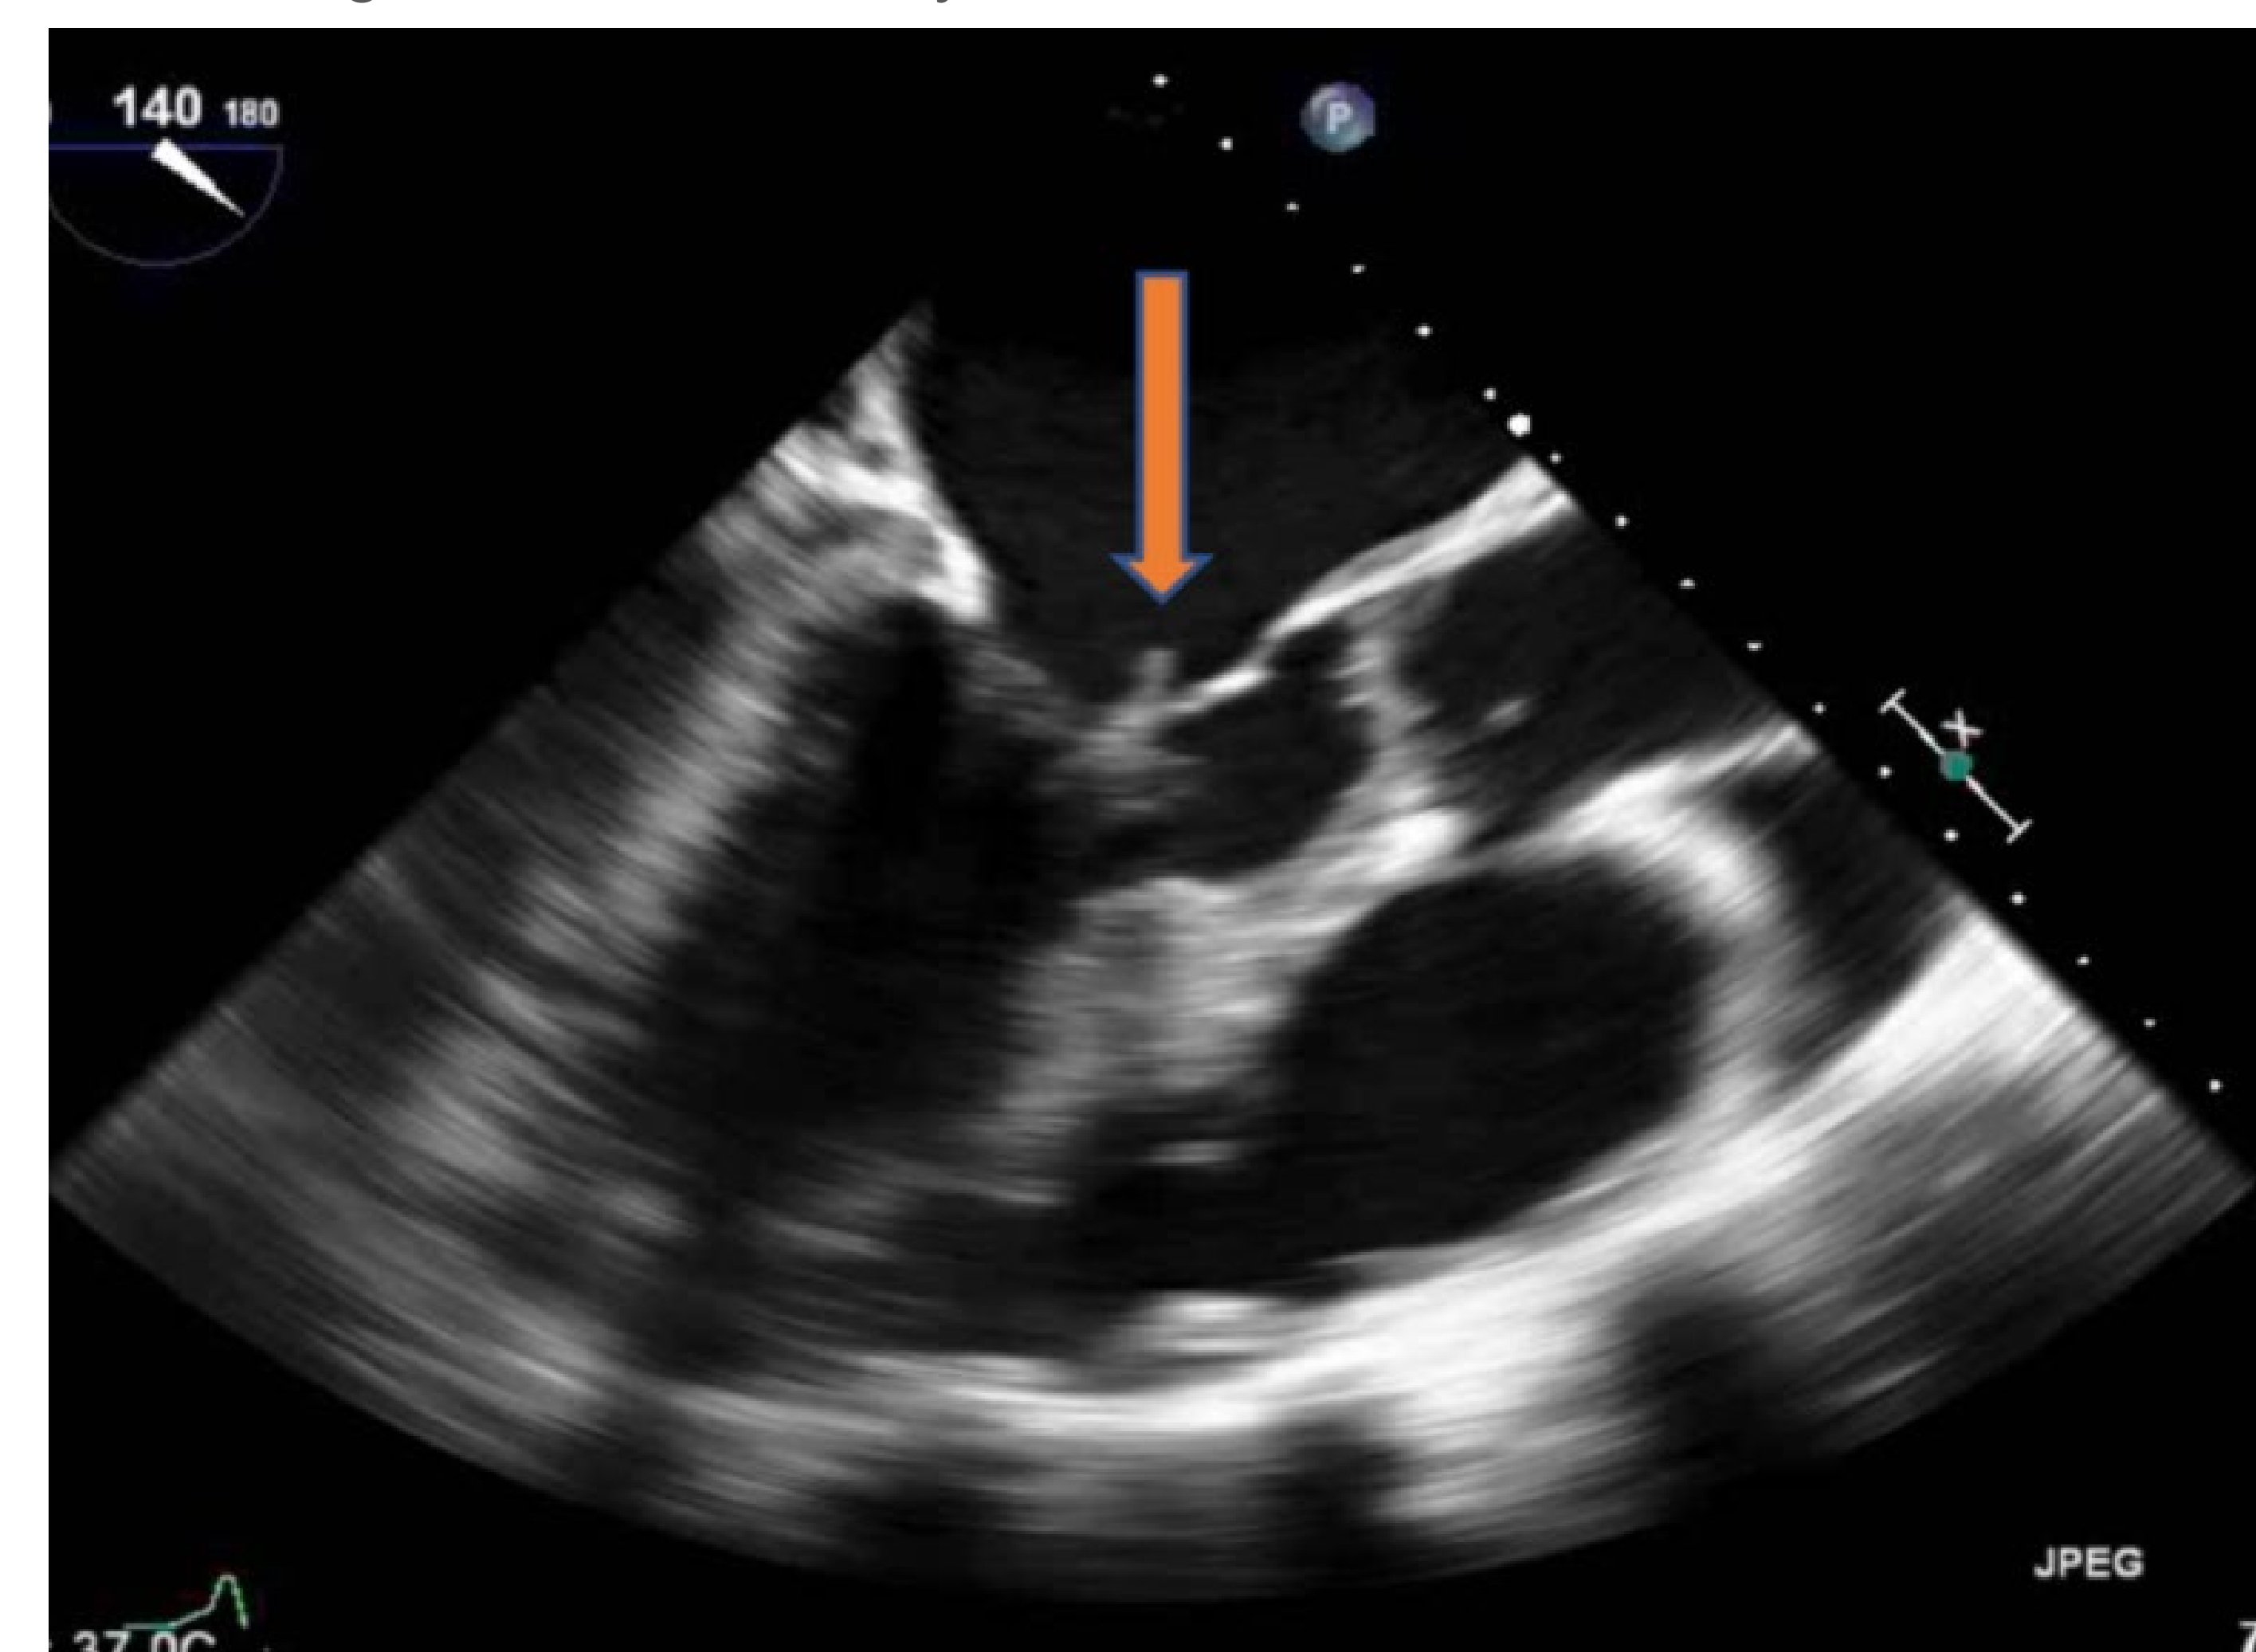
Echocardiogram showing vegetation in the native anterior mitral valve leaflet (arrow).¹¹
